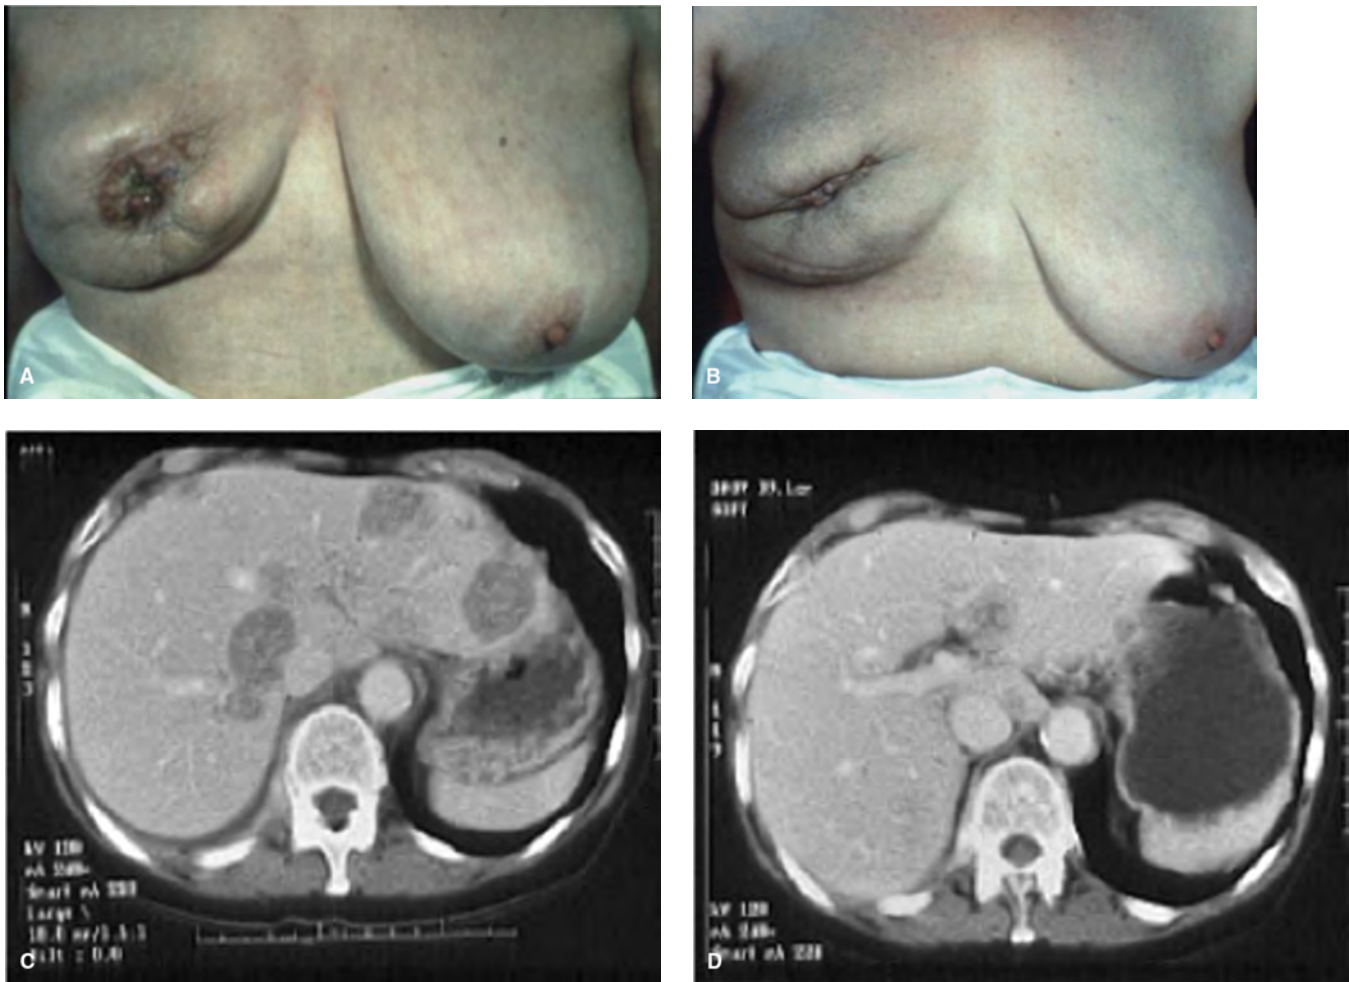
(A) An elderly woman with a locally advanced ER positive (+ve) slow growing right breast cancer at the time of diagnosis prior starting systemic treatment. (B) Excellent response with significant tumor shrinkage after 6 months of endocrine therapy (tamoxifen). (C and D) Transaxial scan CT images of a patient with limited number of lesions and preserved organ function at baseline (C) and after aromatase inhibitor-based therapy (D) showing partial response.
